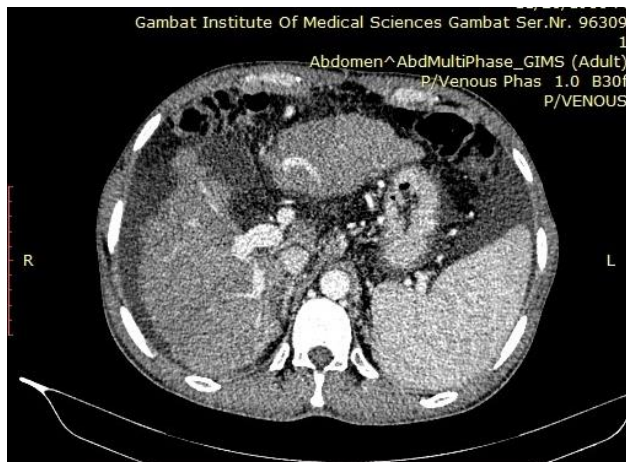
CT scan Abdomen (Porto-venous phase) showing cirrhotic liver with patent portal vein
